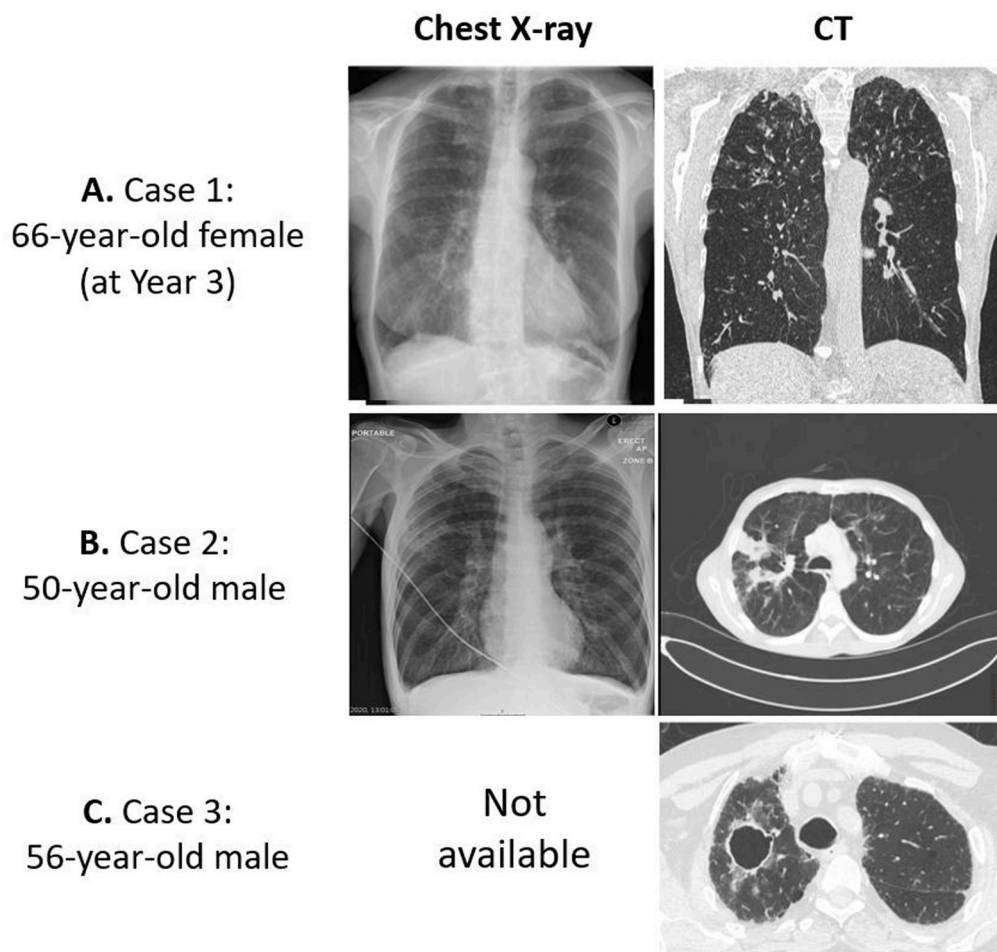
Radiological results from the case studies of patients with NTM-PD. CT, computed tomography; NTM-PD, pulmonary disease caused by non-tuberculous mycobacteria.
